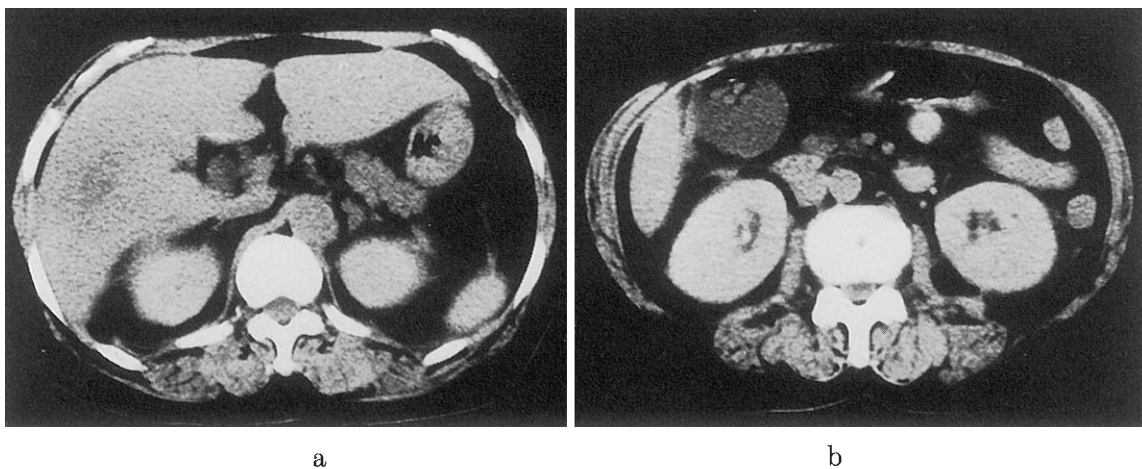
Abdominal CT scans obtained on June 23, 1994. (a) Unenhanced CT scan demonstrated a low density area in the right hepatic lobe. (b) Unenhanced CT scan demonstrated a swollen gallbladder with an air layer inside.
